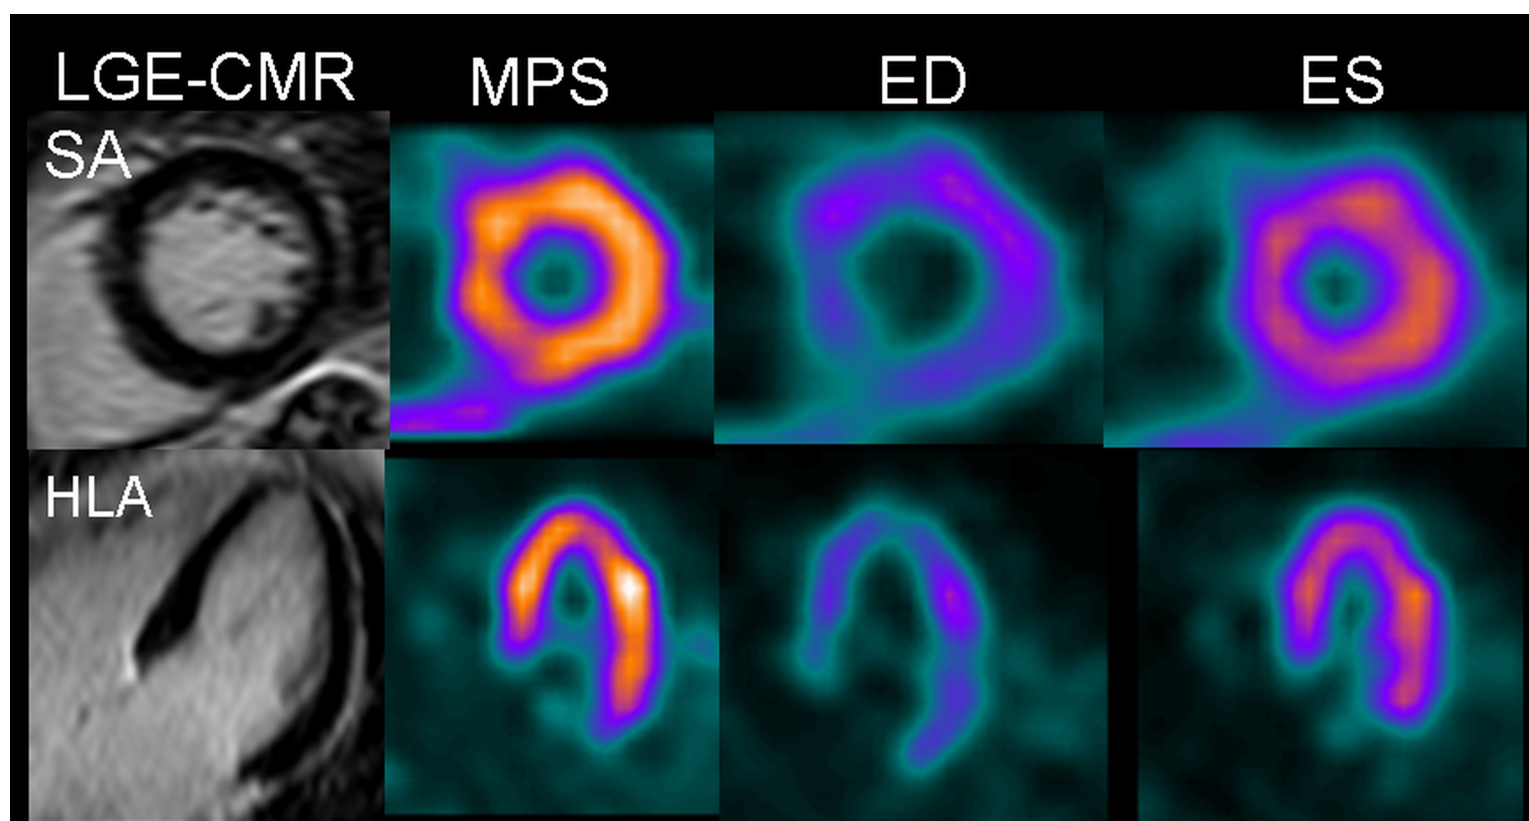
True negative myocardial perfusion SPECT (MPS). CMR excludes infarct. MPS shows no perfusion defect and normal function at gated SPECT. ED end-diastole, ES end-systole, SA short-axis, HLA horizontal long-axis.
